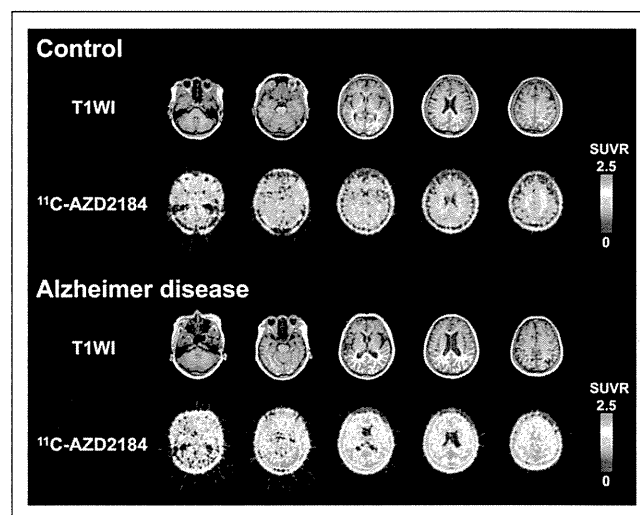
Representative SUVR images of ^{11}C -AZD2184 binding in control subject and AD patient. Integration interval was 40–60 min. Corresponding MR images (T1-weighted [T1WI]) are shown. Scale maximum and minimum values are 2.5 and 0 of SUVR. All images are transaxial sections, and anterior is at top of image and subjects' right is at left.
